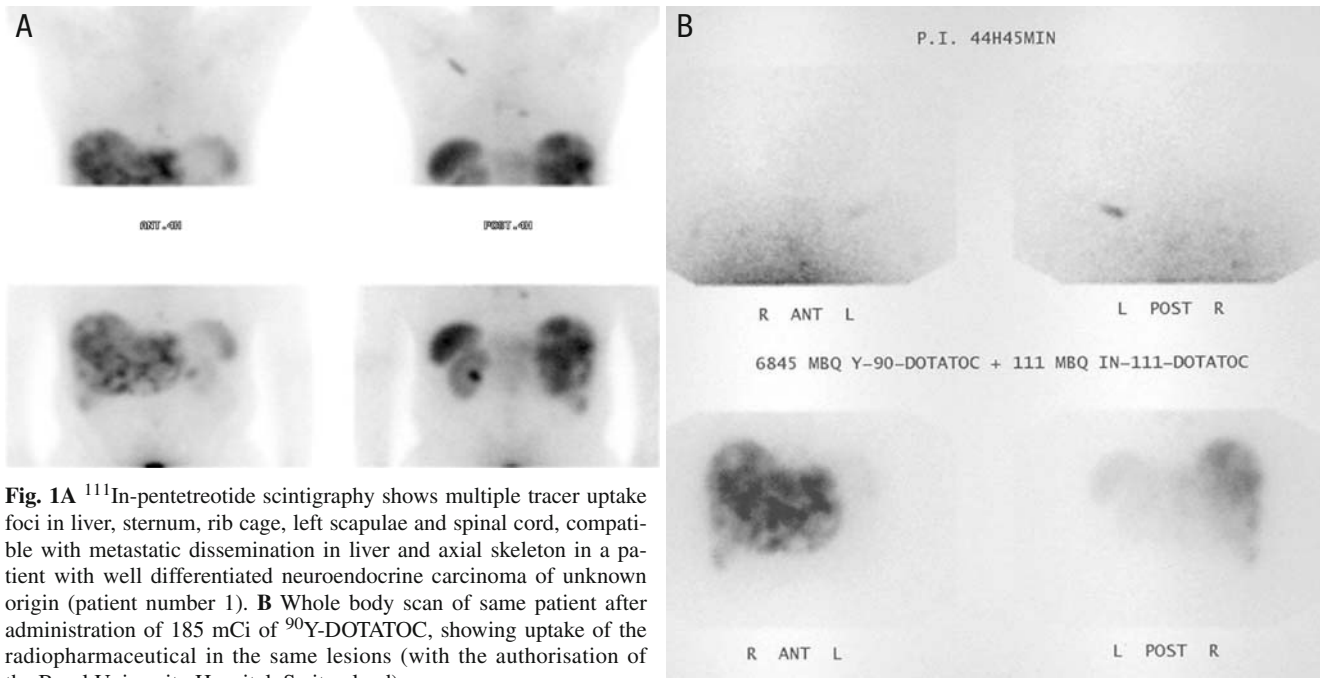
^{111}In -pentetreotide scintigraphy shows multiple tracer uptake foci in liver, sternum, rib cage, left scapulae and spinal cord, compatible with metastatic dissemination in liver and axial skeleton in a patient with well differentiated neuroendocrine carcinoma of unknown origin (patient number 1). B Whole body scan of same patient after administration of 185 mCi of ^{90}Y -DOTATOC, showing uptake of the radiopharmaceutical in the same lesions (with the authorisation of the Basel University Hospital, Switzerland)
